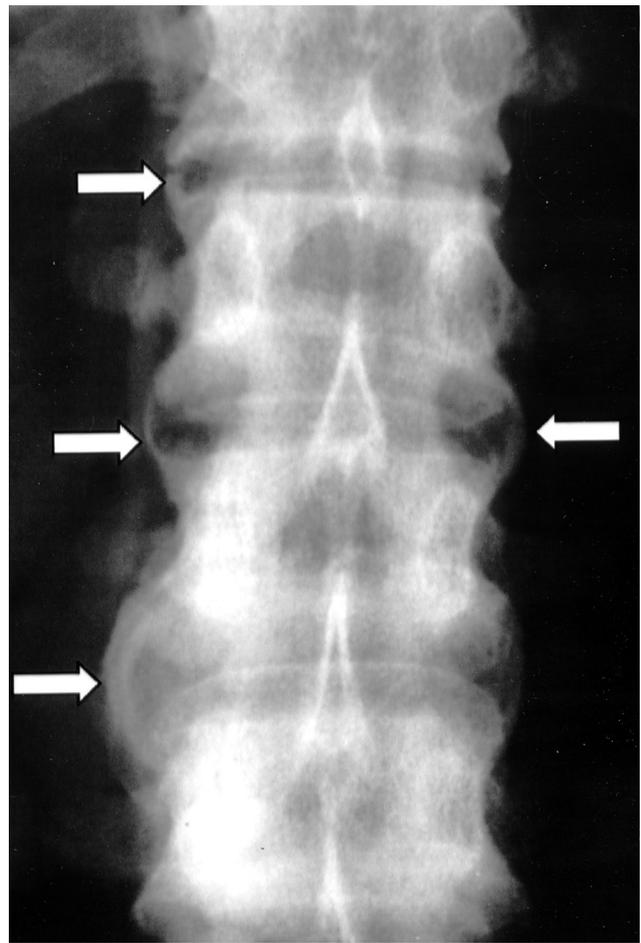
Spine radiographs: lumbar syndesmophytes (arrows).
